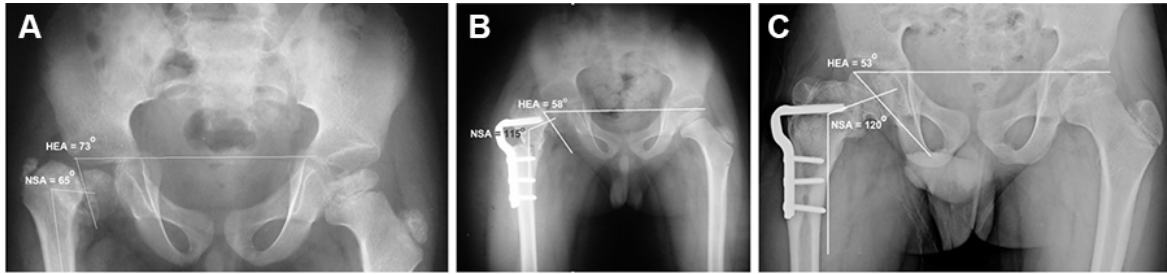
The radiograph both hips of 10-year-old male came with coxa vara from multiple epiphyseal dysplasia (third case) show Hilgenreiner-epiphyseal angle and neck-shaft angle at preoperative, 12 weeks postoperative and final follow-up at 5 years postoperative.
